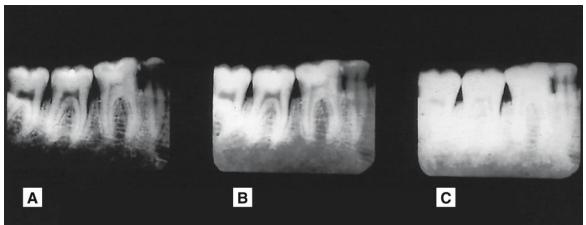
Radiographs of the same area showing variation in contrast – the visual difference in the black, white and grey shadows owing to the penetration of the X-ray beam. (A)
